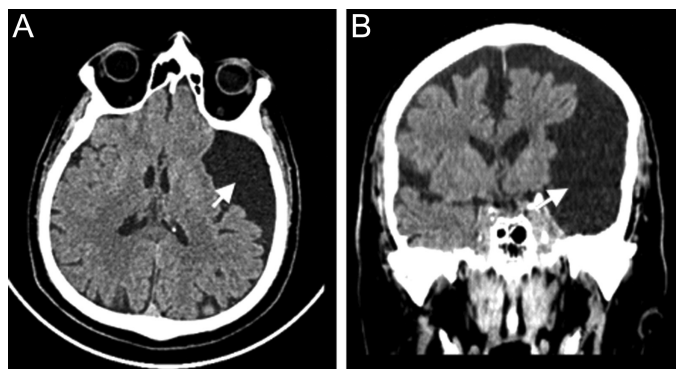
Computed tomography images of the patient a year ago: (A) Axial computed tomography: left-sided incidental $7 \times 5 \times 5$ cm Galassi type 3 arachnoid cyst (white arrow). (B) Coronal computed tomography: incidental left-sided $7 \times 5 \times 5$ cm Galassi type 3 arachnoid cyst (white arrow) displaces temporal lobes significantly and parietal and frontal lobes mildly.
